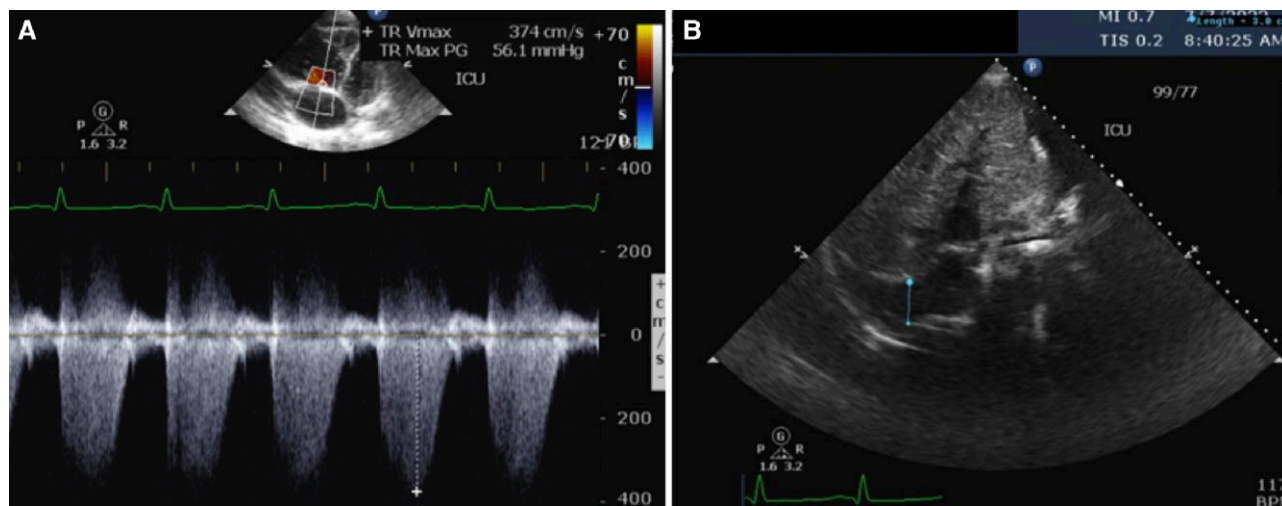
Admission transthoracic echocardiogram (TTE): severely elevated pulmonary artery systolic pressure. (A) Apical view with tricuspid regurgitation pressure gradient of 56.1 mmHg. (B) Non-collapsible inferior vena cava dilated to 3.0 cm (patient not intubated). RA pressure is 15 mmHg. Calculated PASP is 71.1 mmHg. PASP, pulmonary artery systolic pressure; RA, right atrium; TTE, transthoracic echocardiogram.
